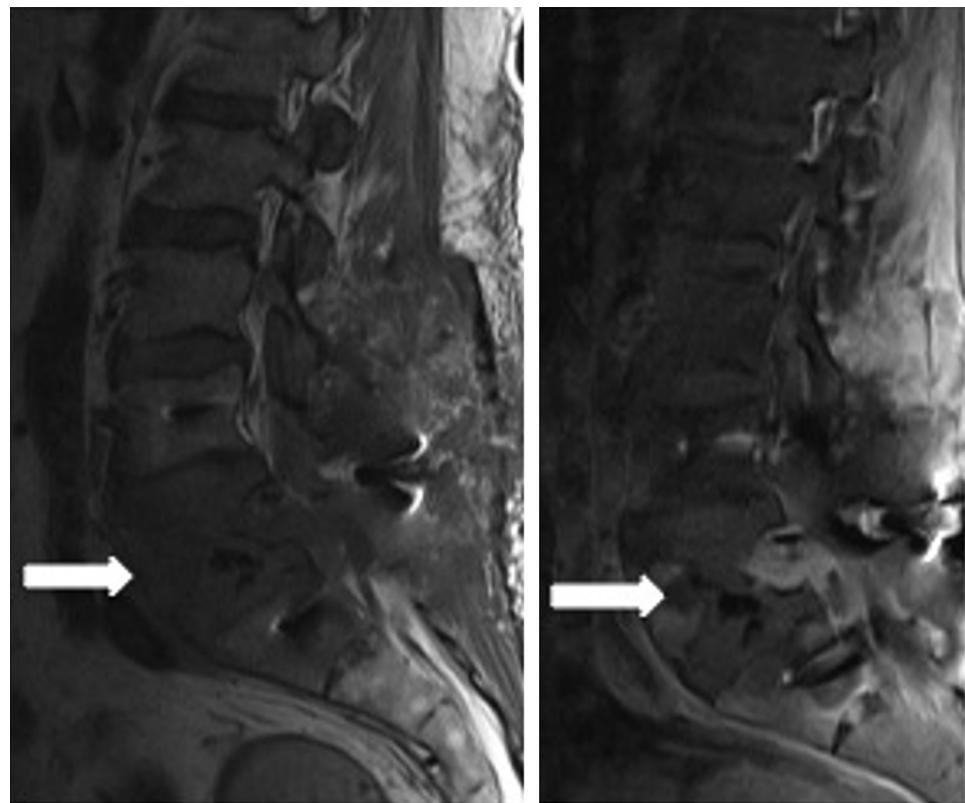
(Left) Sagittal precontrast T1-weighted image demonstrates hypointense mass (arrow) at L5 extending into the ventral epidural space. (Right) Sagittal postcontrast T1-weighted image shows avid enhancement of the L5 lesion (arrow).
